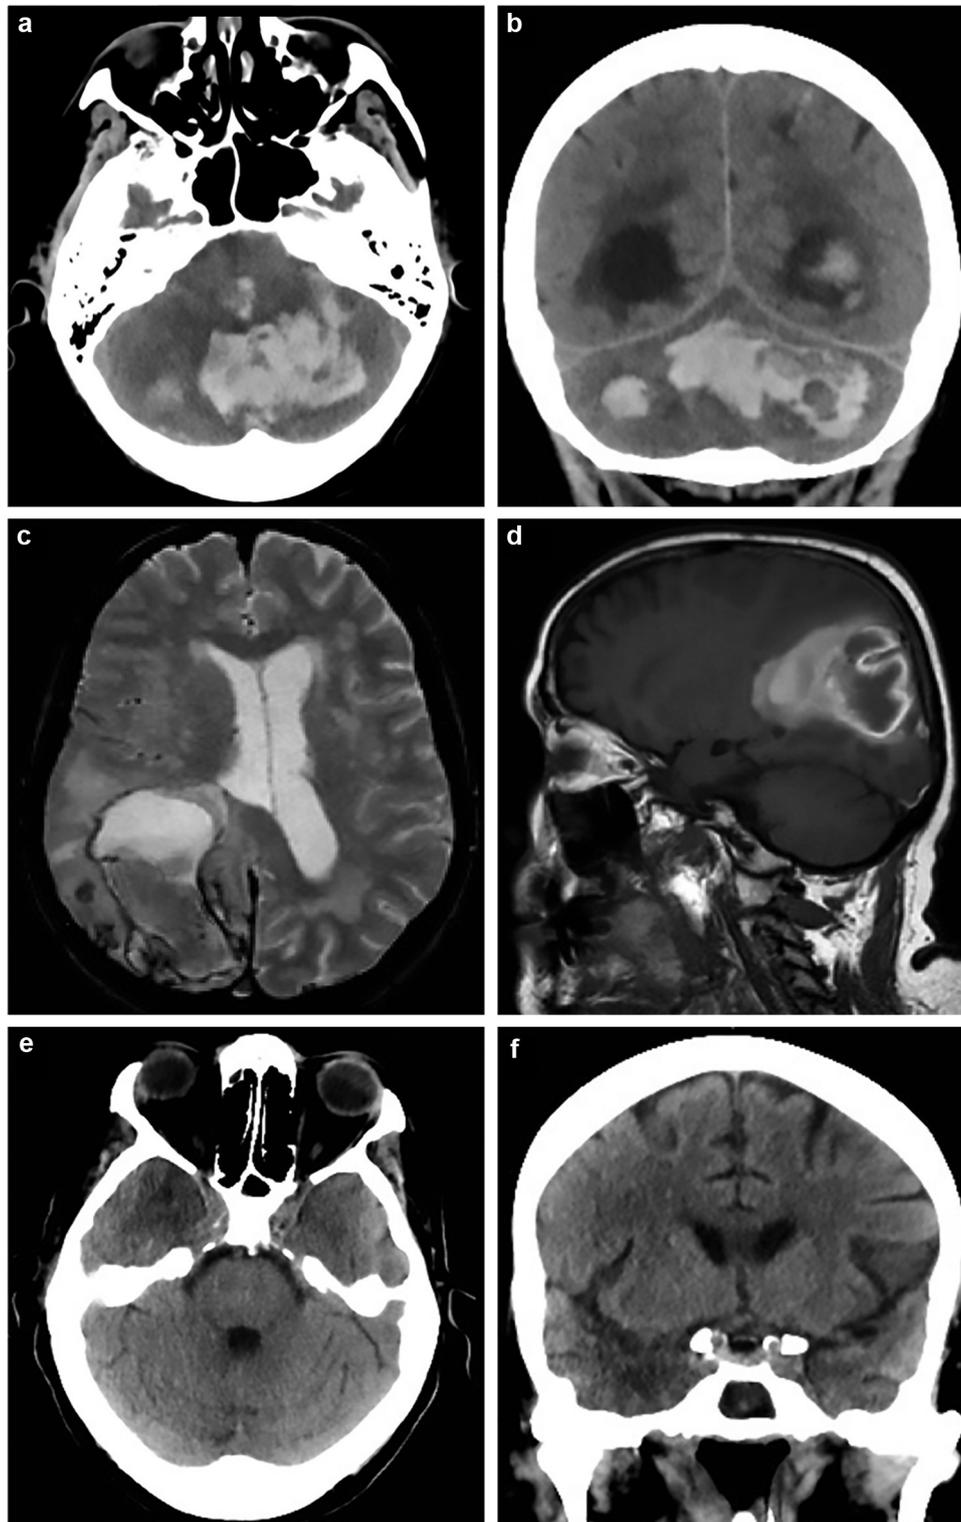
It shows three SARS-CoV-2 patients with cerebral imaging studies. The first case was evaluated with non-contrast CT, A axial and B coronal show massive bilateral cerebellar parenchymal and intraventricular hemorrhage. The second case underwent magnetic resonance imaging brain evaluation and shows: C axial T2 gradient echo and D sagittal T1 spin-echo highlights wide right parieto-occipital hemorrhage. Last patient, evaluated with brain CT, reveals on E axial and F coronal plans right temporal lobe hypodensity; no acute ictal clinical onset, in addition with the isolated involvement of white substance, made us suggest that the lesion could be related to an inflammatory process.
